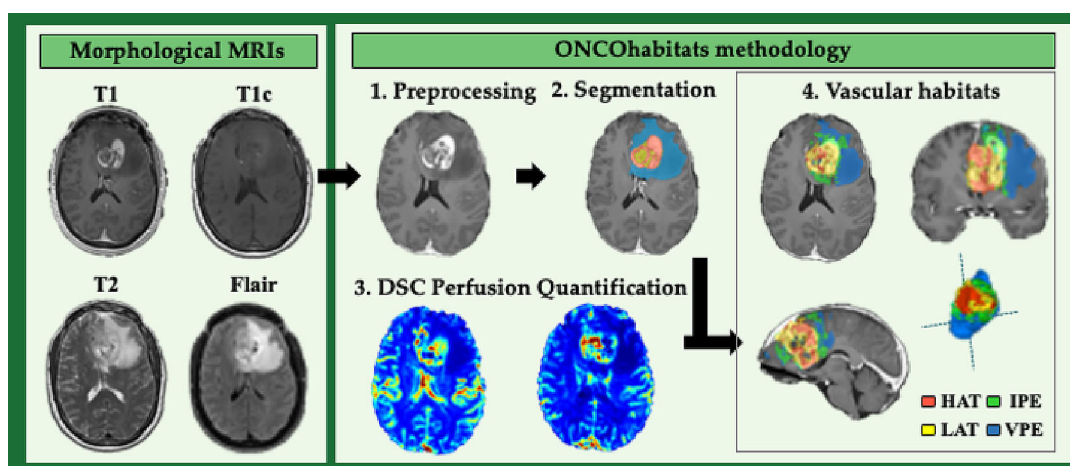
The ONCOhabitats methodology includes four stages: (1) preprocessing; (2) glioma segmentation in classical tissues: active tumor, edema, and necrosis; (3) DSC perfusion quantification; and (4) HTS habitats: high angiogenic tumor (HAT), low angiogenic tumor (LAT), infiltrated peripheral edema (IPE), and vasogenic peripheral edema (VPE). DSC, dynamic susceptibility contrast; FLAIR, fluid-attenuated inversion recovery; HTS, hemodynamic tissue signature.
